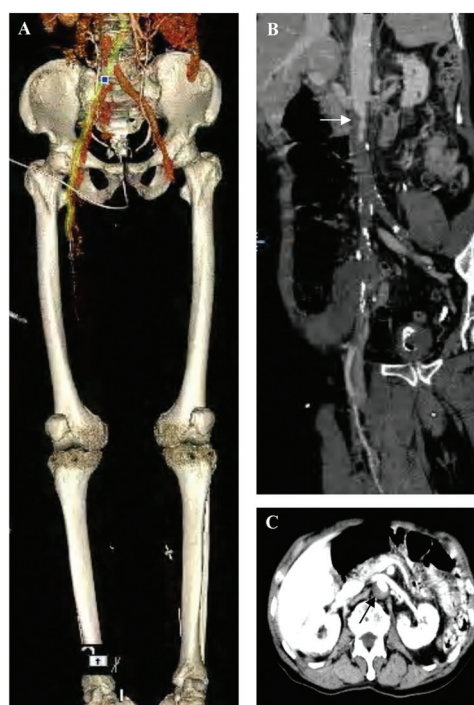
The whole image (A), 3-dimensional computed tomography image (B), and cross-sectional computed tomography images (C) of the patient. Arrows refer to the aortic occlusion position.
